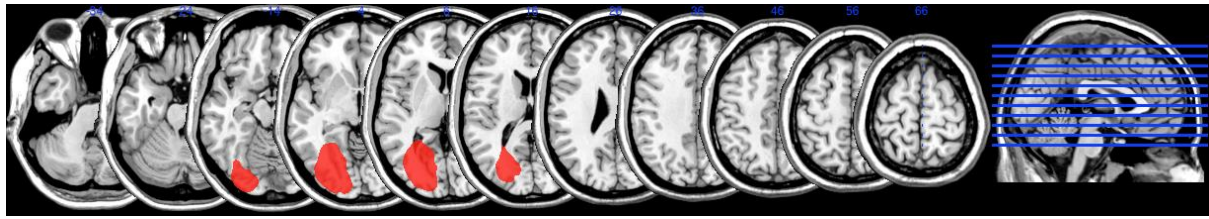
MRI scan of patient SH
